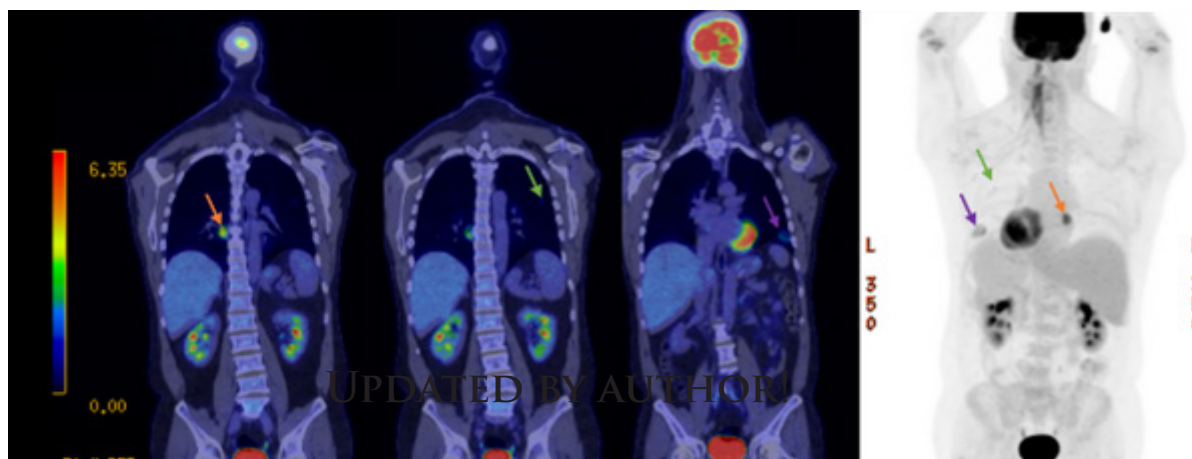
PET CT demonstrating a hypermetabolic left upper lobe nodule (green arrow), left lower lobe mass (purple arrow) and right lower lobe pleural-based mass (orange arrow).
